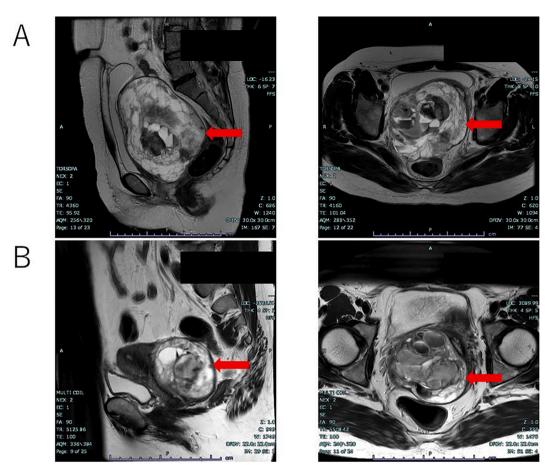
Pelvic magnetic resonance imaging findings at first visit and first recurrence. (A) At the first visit, a tumor suspected of degenerative myoma was found in the pelvis. (B) The tumor recurred in the posterior wall of the uterine cervix.
